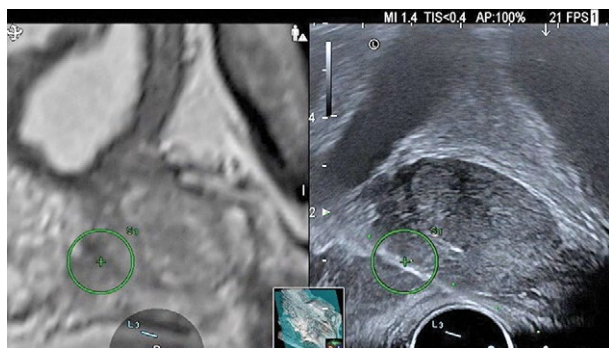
A 60-year-old patient with a PSA of 5.8 ng/ml and a PIRADS score 3 lesion at the base of the right prostate lobe. An MRI-TRUS fusion biopsy was performed and confirmed the diagnosis of PCa Gleason score 7(3+4), with 1/2 and 4/12 positive targeted and systematic cores, respectively.
